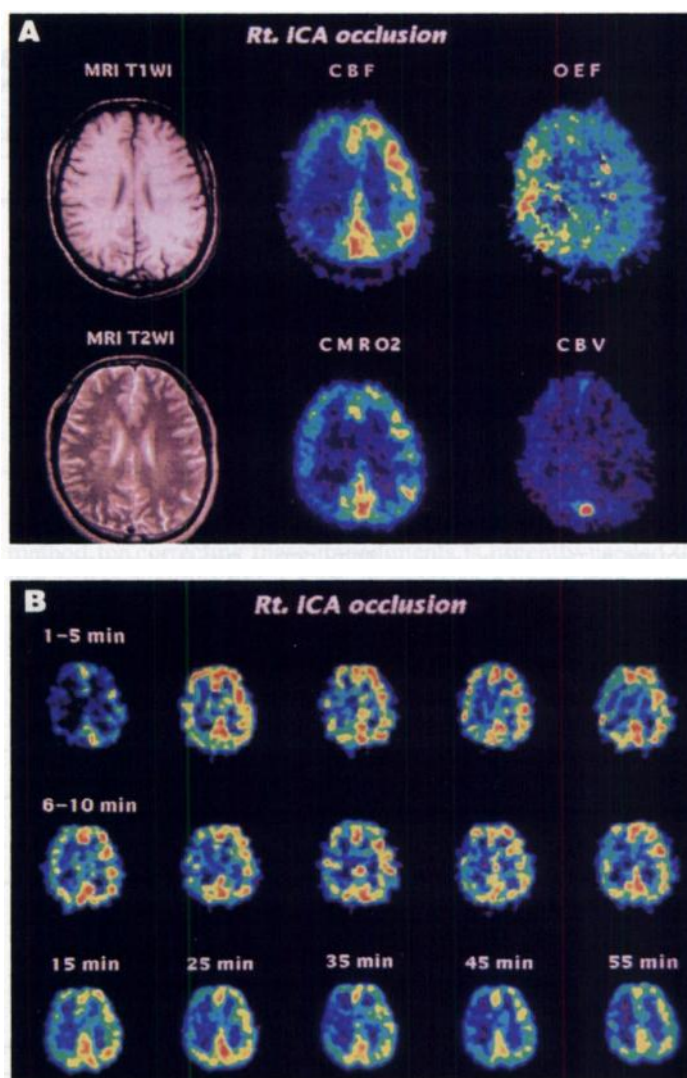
(A) MRI and PET images in Patient 11. T2-weighted MRI obtained 12 days after initial symptom onset (left column) demonstrates an infarction observed only in the right deep white matter and that the peri-infarct cortices remain morphologically intact. High OEF of the affected cortex indicates uncoupling between CBF and oxygen metabolism (right column). (B) Dynamic and static ^{99m}Tc -ECD SPECT images in the corresponding plane in the same patient show slightly diminished contrast between the affected and unaffected cortices 2 min after injection compared to the initial dynamic SPECT and PET CBF image.
